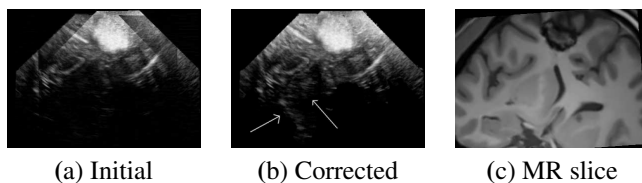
Impact of the shadow estimation on the reconstruction of 3D intraoperative brain ultrasound images. A sequence of 3D freehand ultrasound was acquired during brain surgery. During the sequence, two sweeps were done with different viewing angles. The two sweeps are compounded in one reconstructed volume. Image (a) shows a slice of the reconstructed volume with a Distance-Weighted reconstruction method. Reconstruction artifacts are visible on the boundaries of anatomical structures (sulci and cerebral falx). When incorporating the shadow estimation mask (figure (b)), artifacts are removed and deep structures appear clearly. The "border artifacts" at the left and right of the image are due to the B-scan mask that has been taken into account when reconstructing image (b).
